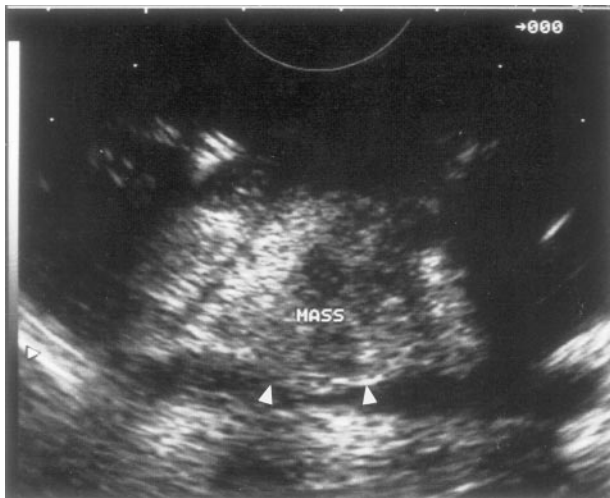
Endoscopic ultrasound demonstrating vascular involvement: tumor (mass) encroaching on the portal vein (white arrows).
